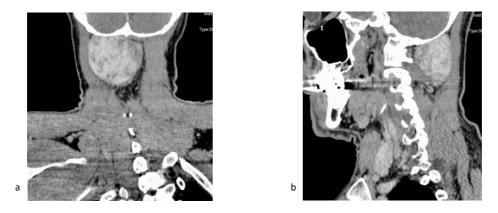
Computed tomography (TC) scan revealed a well-defined, ovoid mass; a): frontal view b): lateral view.
